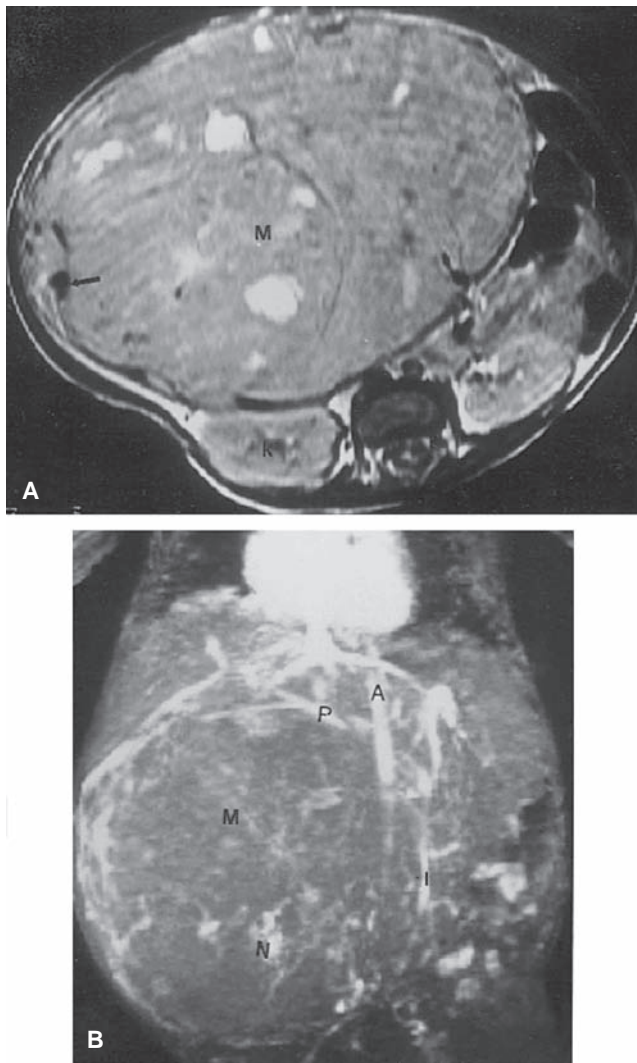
A: Hepatoblastoma in a 2-month-old boy. Axial T1 magnetic resonance imaging (MRI) shows a solid mass (M) occupying entire liver, gallbladder (*arrow*), and right kidney (K). B: Coronal magnetic resonance angiography shows liver mass (M), with stretching of the hepatic vessels and multiple area of neovascularity (N). Note marked stretching and displacement of the inferior vena cava (I) with patent portal vein (P). A, aorta.
